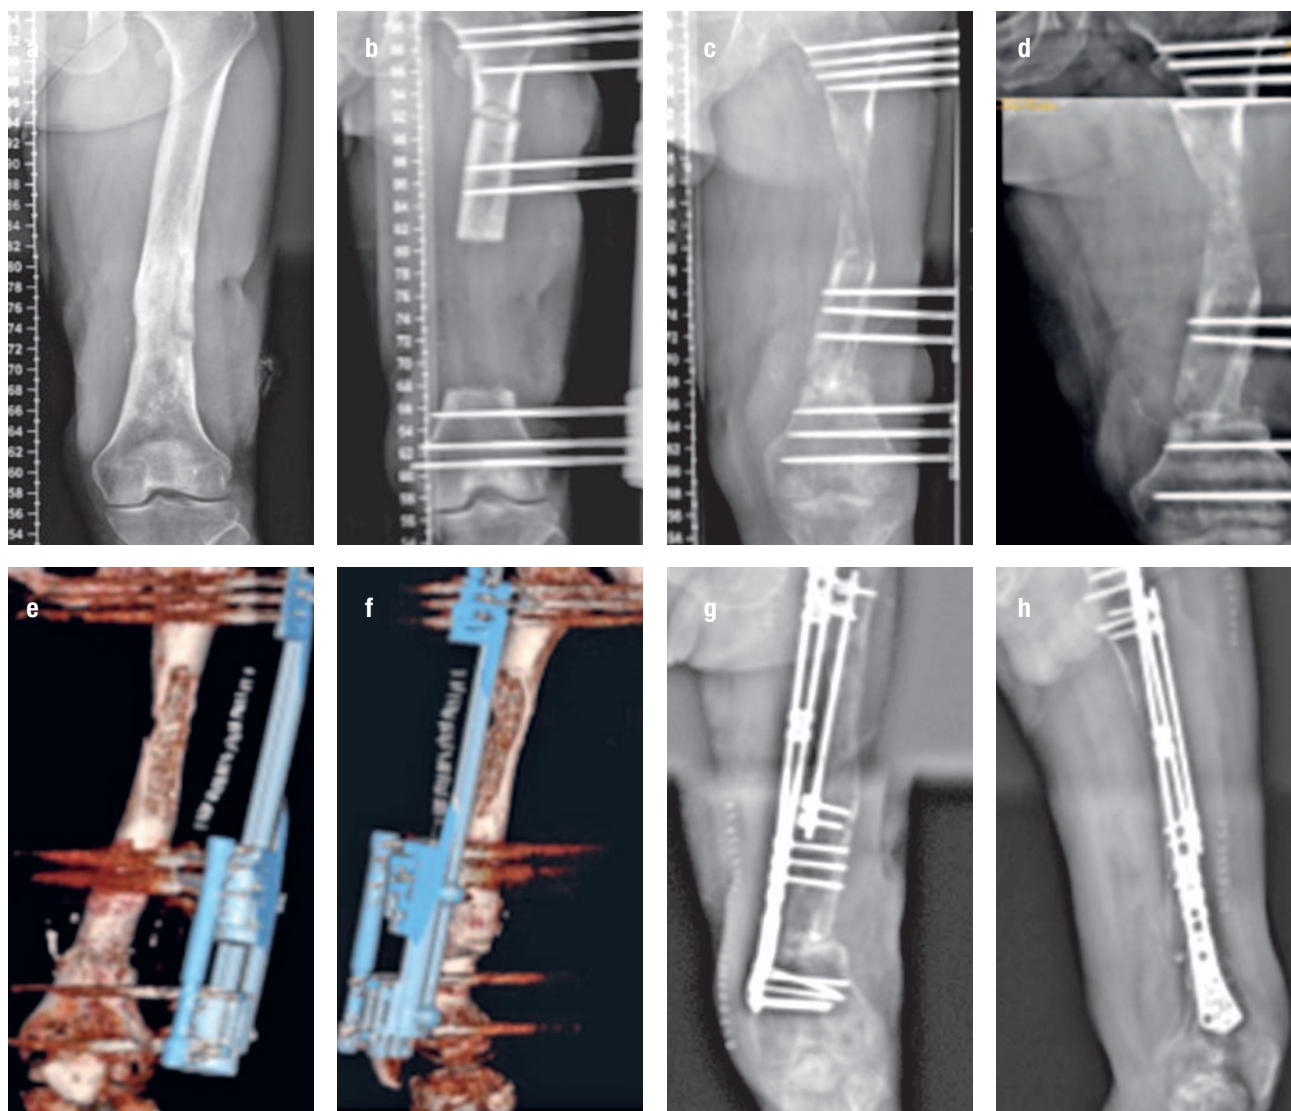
57-year-old male patient underwent bone transport after resection of infected bone segment for chronic osteomyelitis of left femur: (a) the bone transport is performed before femoral anteroposterior X-ray; (b) the infection bone resection and bone transport is performed postoperative femoral anteroposterior X-ray; (c) the bone transport is performed postoperative X-ray; (d) the multiple mechanical weak points in the femur; (e) the CT three-dimensional reconstruction; (f) the CT three-dimensional reconstruction; (g) the 4 months after operation, femoral anteroposterior X-ray; (h) 4 months after operation, femoral lateral X-ray.
